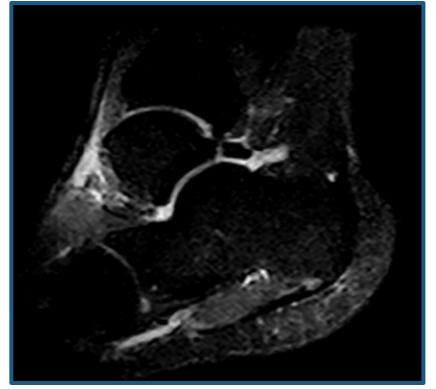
Pre-operative T2- weighted MRI confirming presence of os trigonum noted to the posterior ankle. Concomitant hyper-intense fluid signal surrounding the os and adjacent structures.
